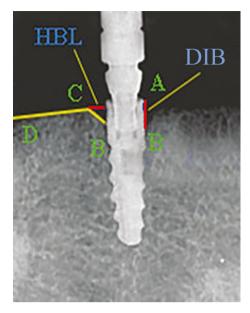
Traced peri-apical radiograph: A; the implant-abutment junction, B; first bone to implant contact, C; marginal bone level [which represents the intersection point of a tangent to the horizontal bone crest (CD line) and another tangent to the crater-shaped defect (CB line)], DIB; vertical bone level, HBL; horizontal bone level.
